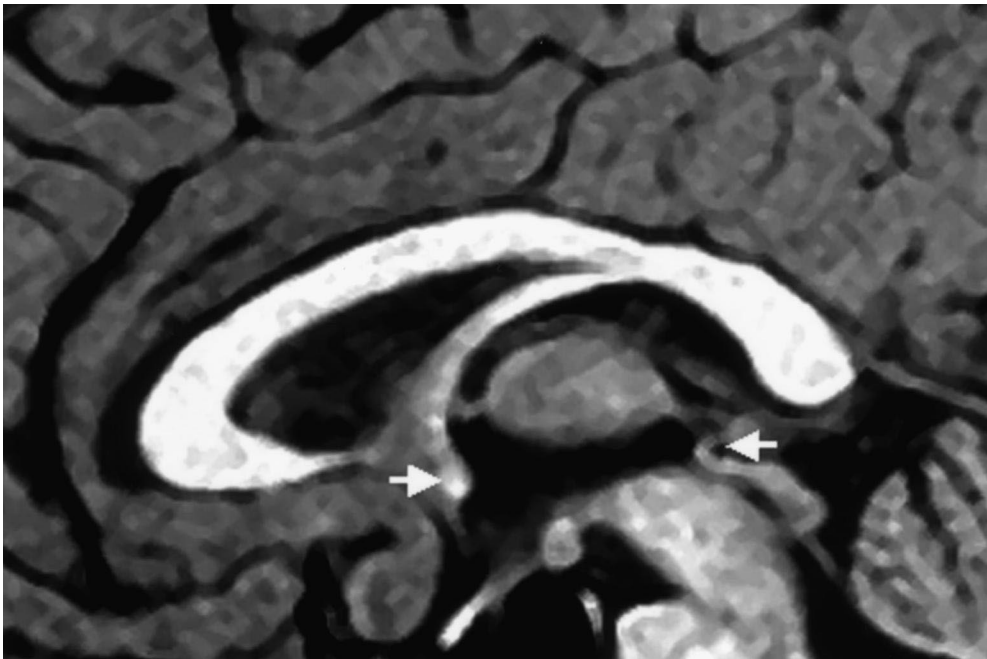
Detail of a midsagittal MRI of the corpus callosum (CC). White arrows indicate the anterior and posterior commissures.
